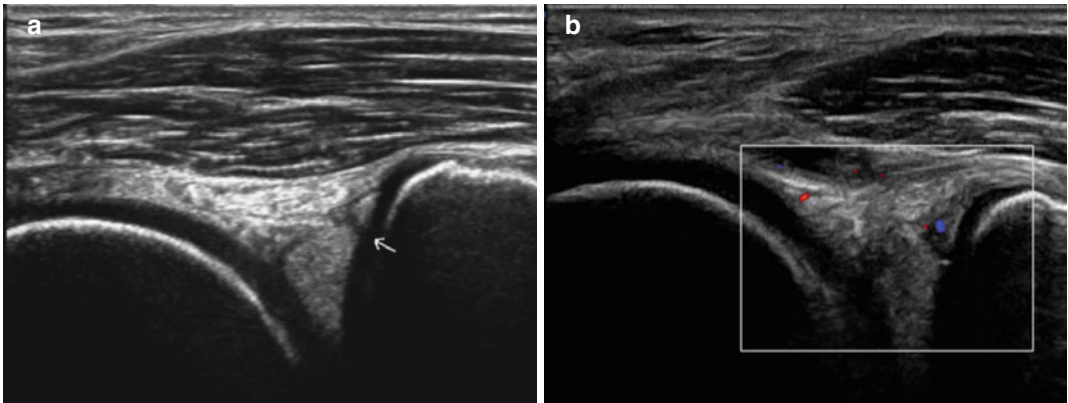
(a) Peripheral Medial Meniscal lesion (b) Vascular Doppler technology
